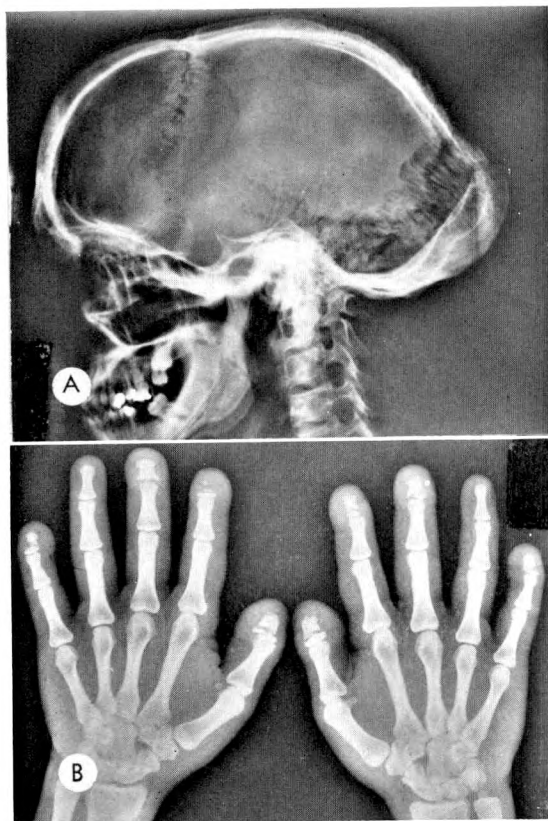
Case IV. (A) Lateral skull roentgenogram showing bathrocephaly, depression at anterior fontanelle, basilar impression and alveolar resorption of mandible and maxilla. (B) Osteolysis of distal phalanges of first, second, third, and fifth digits. Fourth digits are not affected.
